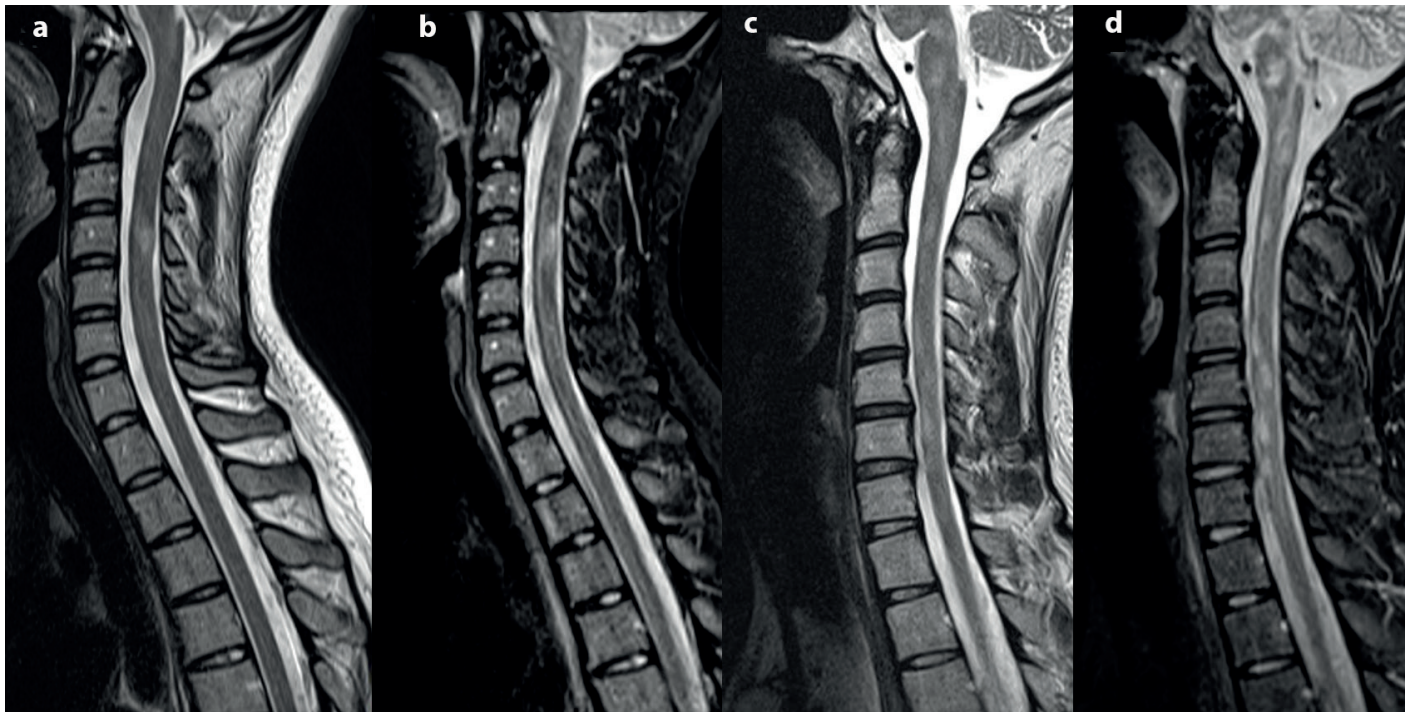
a–d. Sagittal FLAIR (a) and T1-weighted (b) images from the same plane in 28-year-old man and 33-year-old woman with relapsing-remitting multiple sclerosis, shows a few plaques in the cervical spinal cord. In another MS patient MR images shows higher T2 lesion burden in the spinal cord. Note that STIR image (d) is more sensitive in detection of MS plaques than T2-weighted image (c). Spinal cord lesions have a clear role in predicting the accumulation of clinical disability.
